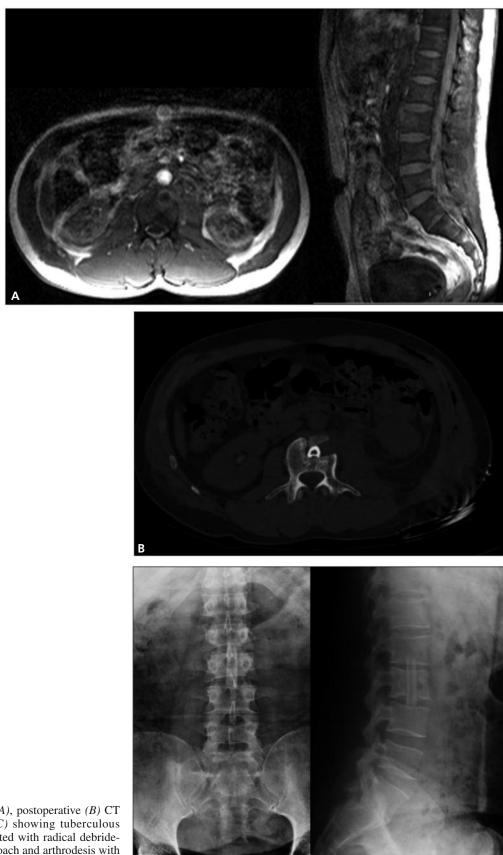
Preoperative (A), postoperative (B) CT and X-ray images (C) showing tuberculous spondylitis of L2 treated with radical debridement by anterior approach and arthrodesis with autogenous rib graft.
